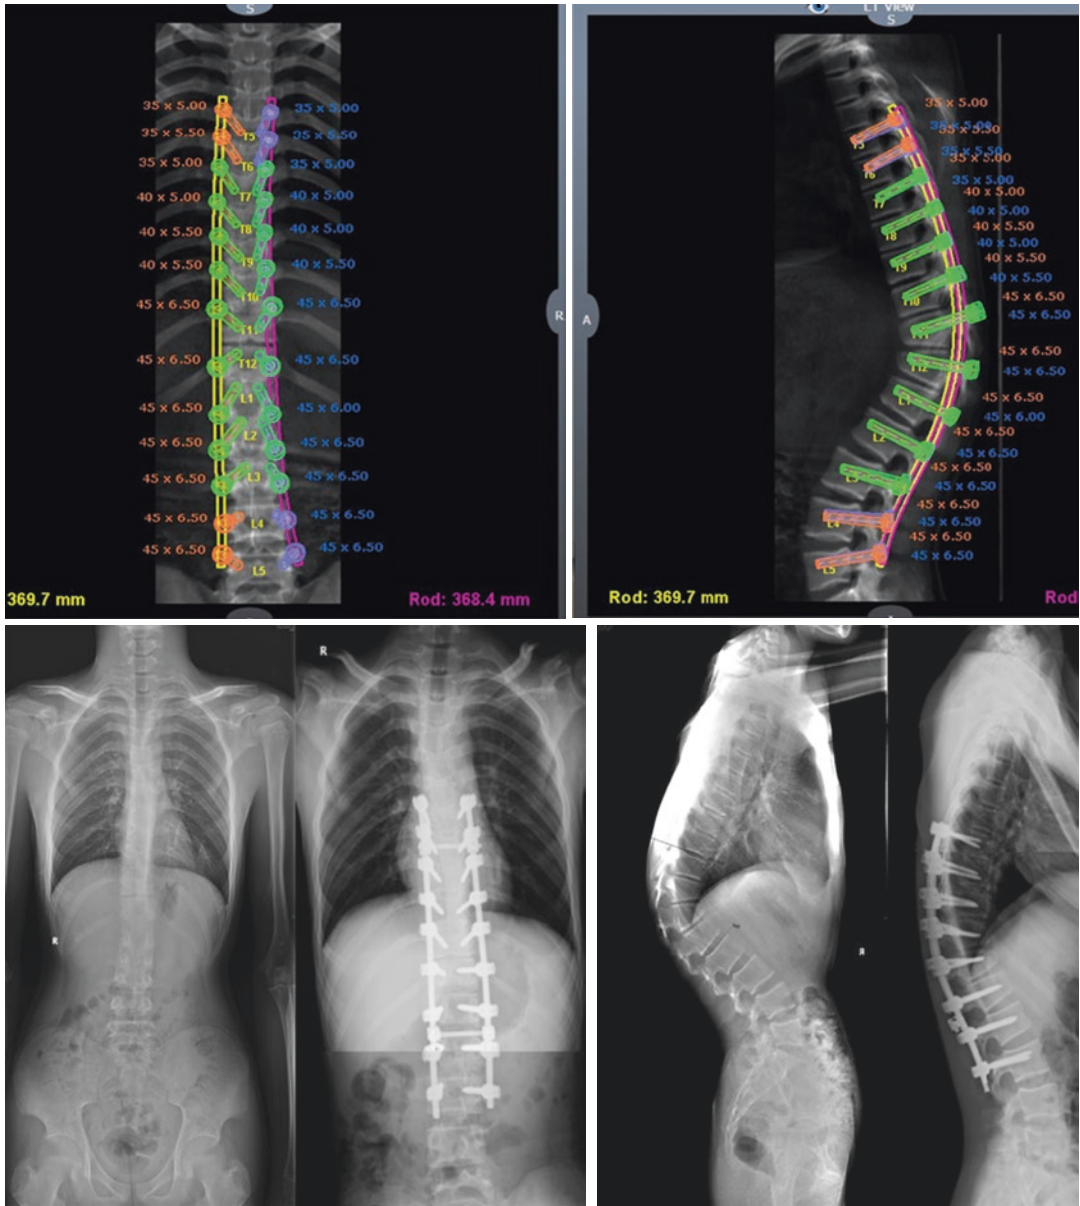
A 14-year-old male, kyphosis for 5 years. Planning for pedicle screw placement via a Robotic-assisted system before the procedure. Postoperative X-ray demonstrated spinal deformity was corrected
